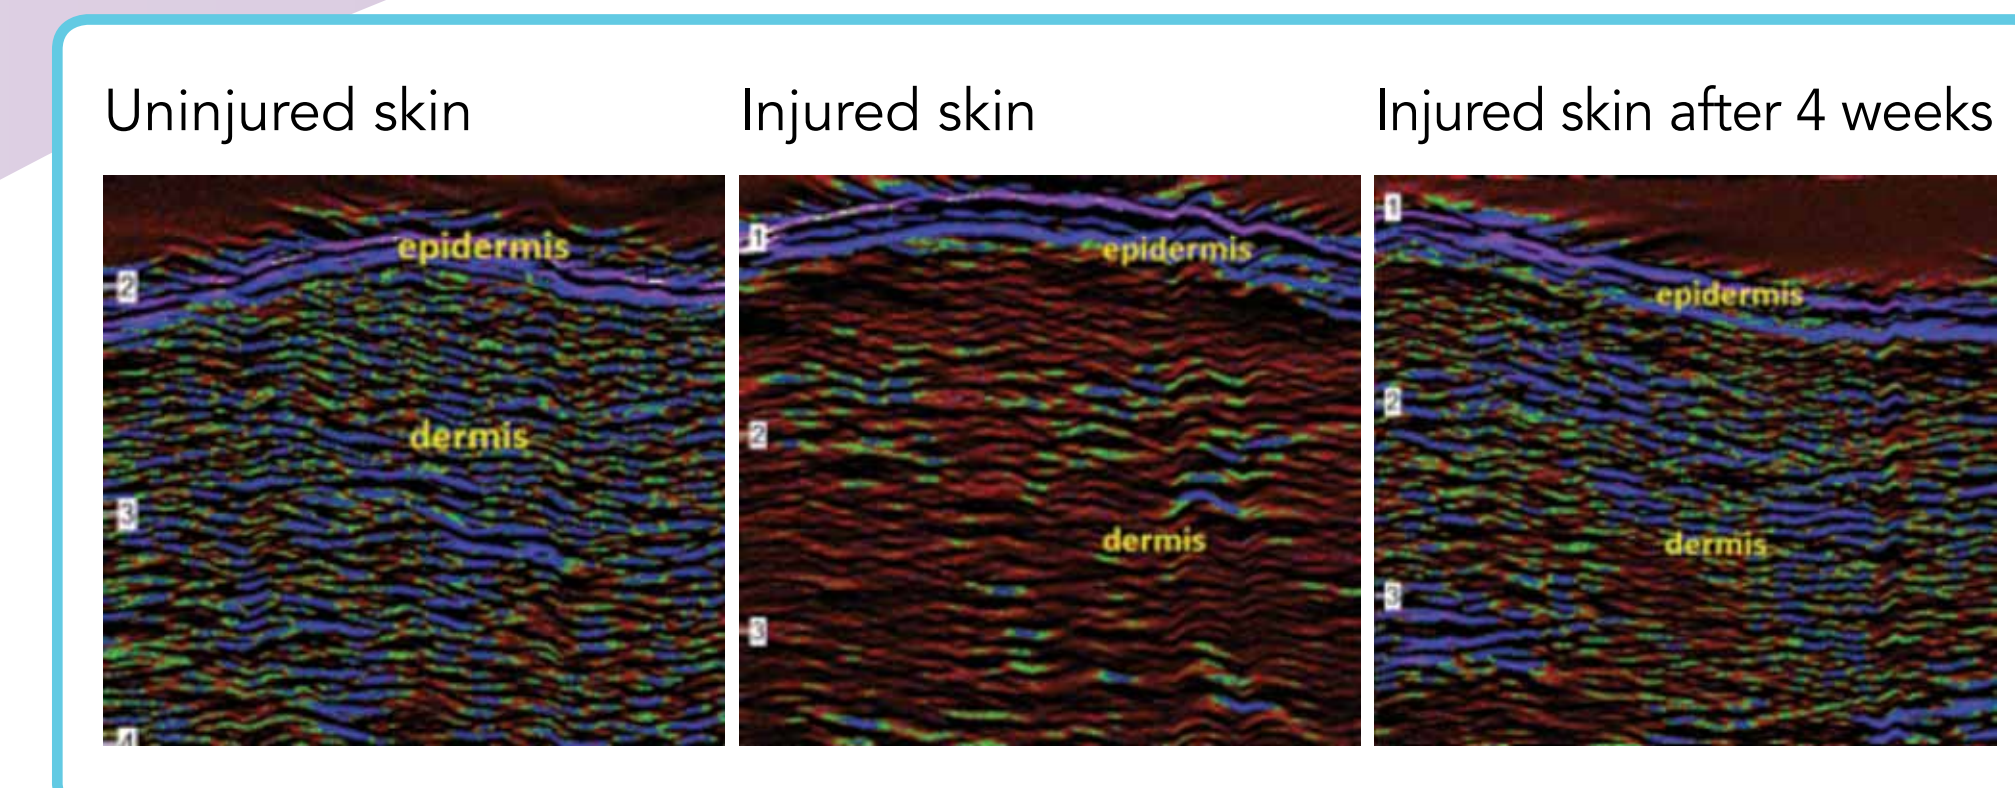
Ultrasound scan of the KerraPro treated heels
